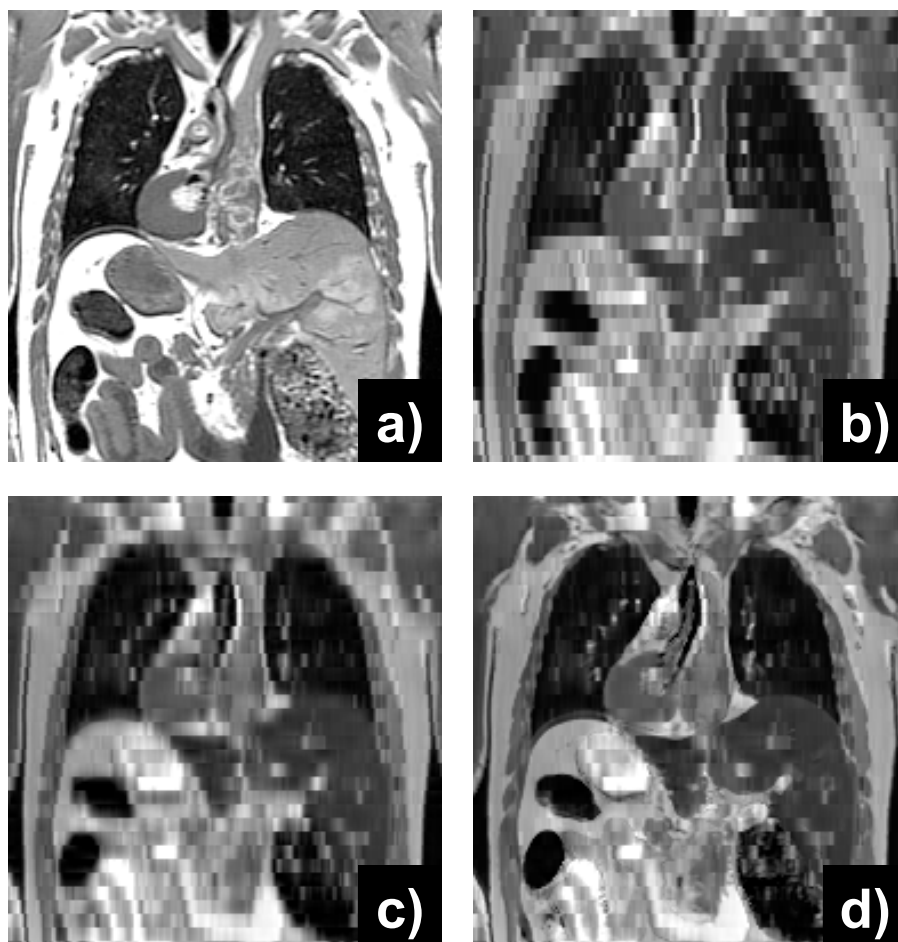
Coronal plane of chest MRI of VHD. (a) HR T1-weighted guidance volume. (b) LR T2-weighted volume (subsampled by a factor of 6). (c) SR reconstruction without registration. (d) SR reconstruction of our proposed method yields a visually clearly improved result. Problematic are areas, which have no corresponding anatomy in the HR scan.
